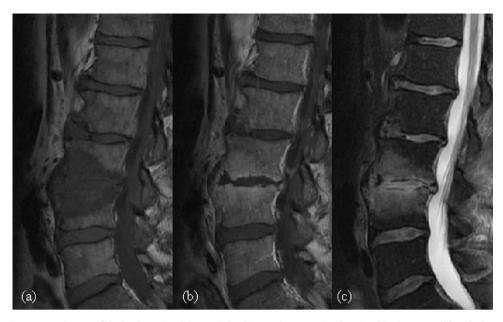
Sagittal magnetic resonance images of the lumbar spine. (a) T1-weighted image demonstrating low signal in the L3–L4 disk and adjacent vertebral bodies with destruction of the superior endplate of L3 and inferior endplate of L4. (b) T1-weighted post-gadolinium image showing enhancement of the L3 and L4 vertebral bodies and the anterior paraspinal soft tissue. (c) T2-weighted image demonstrating increased signal intensity in the L3–L4 disk and the L3 and L4 vertebral bodies.
